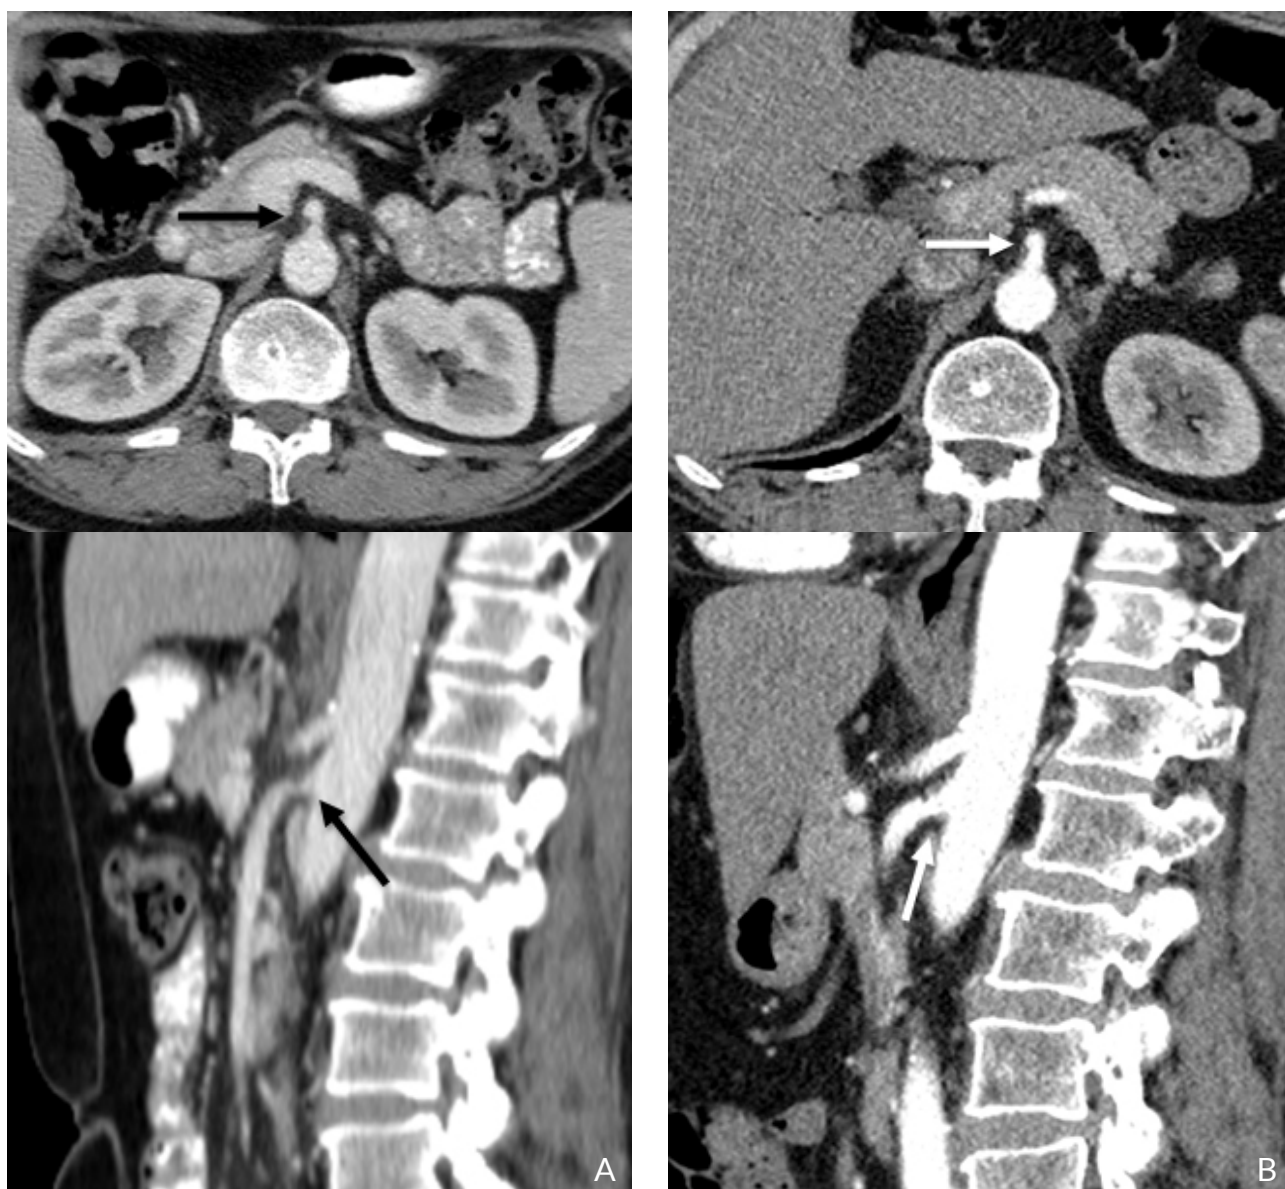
Imaging of changes in superior mesenteric artery (SMA) stenosis. (A) Contrast-enhanced CT of the abdomen revealing eccentric plaque at the origin of the SMA causing 60–80% stenosis (black arrows). (B) CT angiography, performed 4 weeks later, shows regression of the high-degree stenosis to about 20% of the cross-sectional area (white arrows), with disappearance of the flap caused by the ruptured plaque
